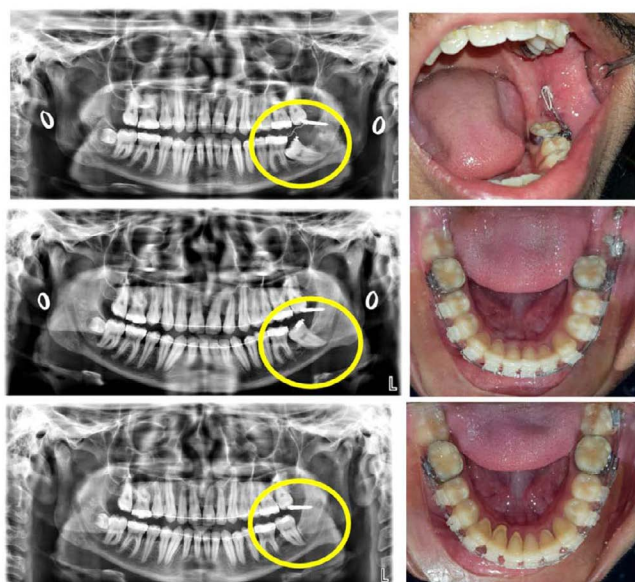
Mid treatment photographs and orthopantomograms showing traction of lower left impacted second molar from the intra-ramal bone screw.
